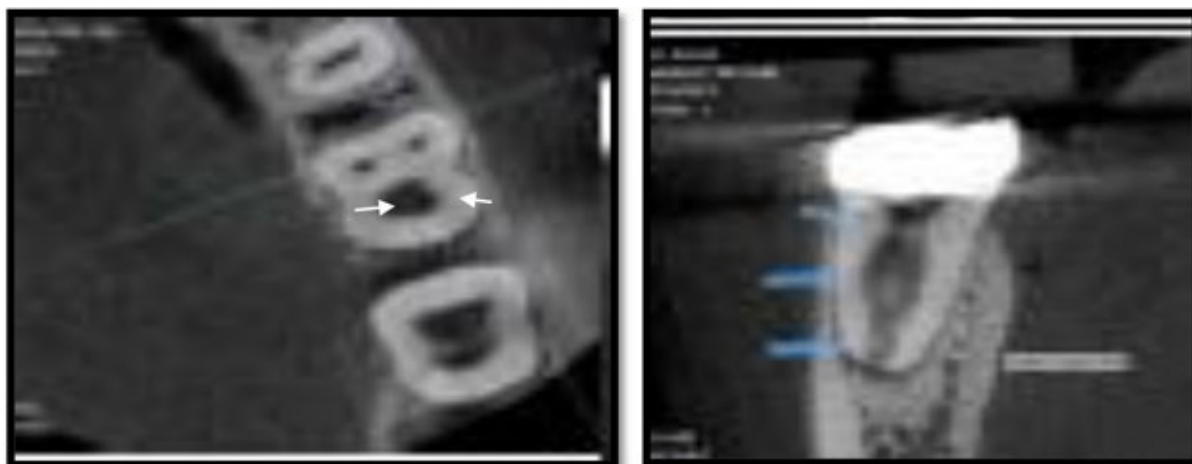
Intraoperative CBCT cross-sections confirm the internal resorption without perforation of radicular walls
